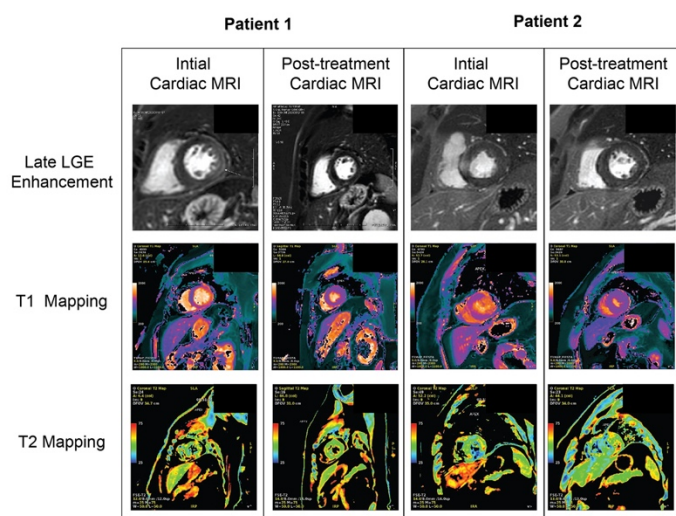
Cardiac MRI findings in patient 1 and 2.
